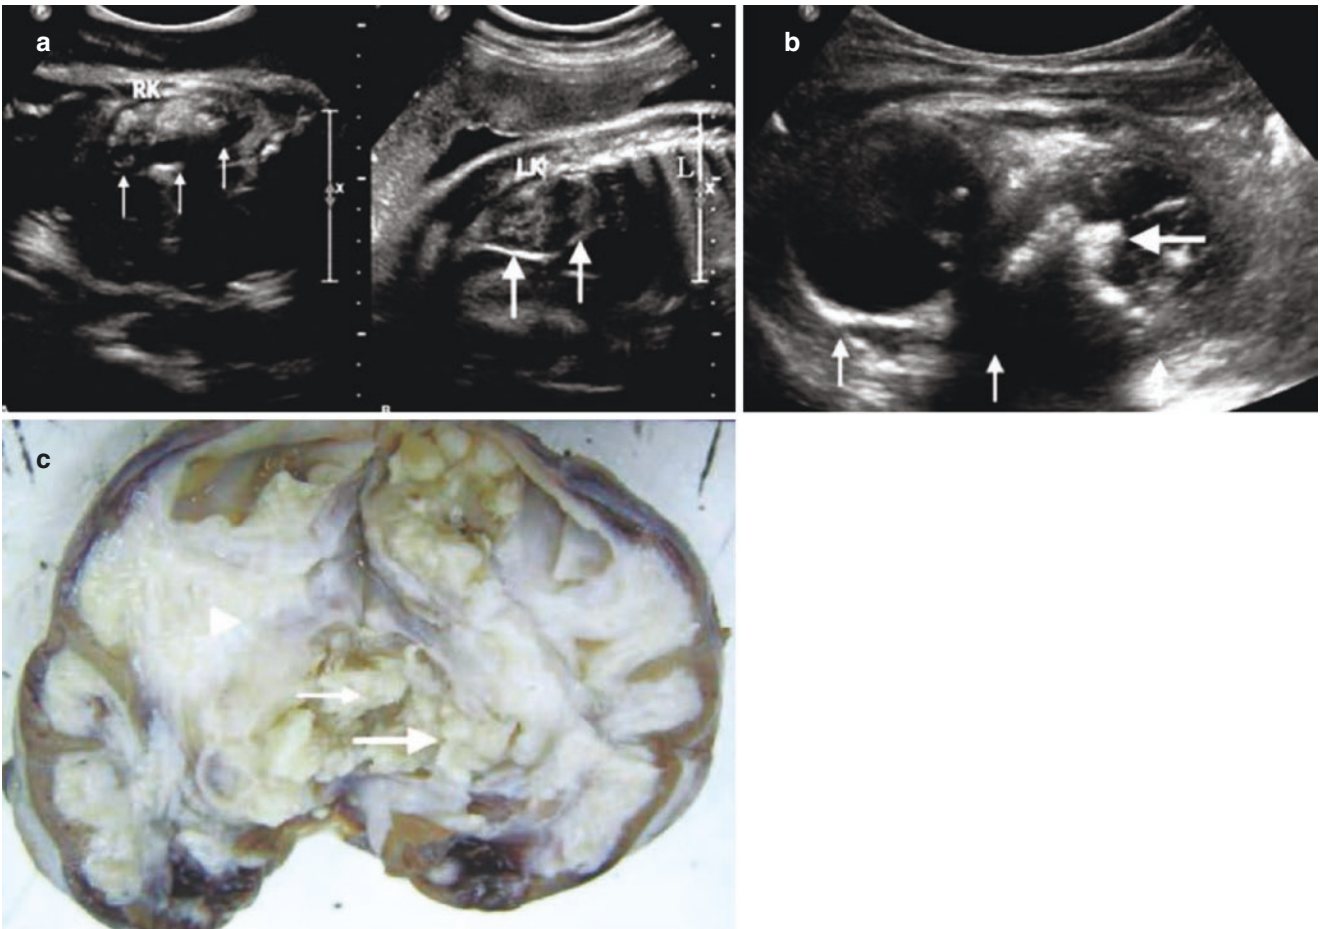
Right renal teratoma. (a–c). The images are prenatal sonogram, postpartum sonogram, and postoperative pathological image
